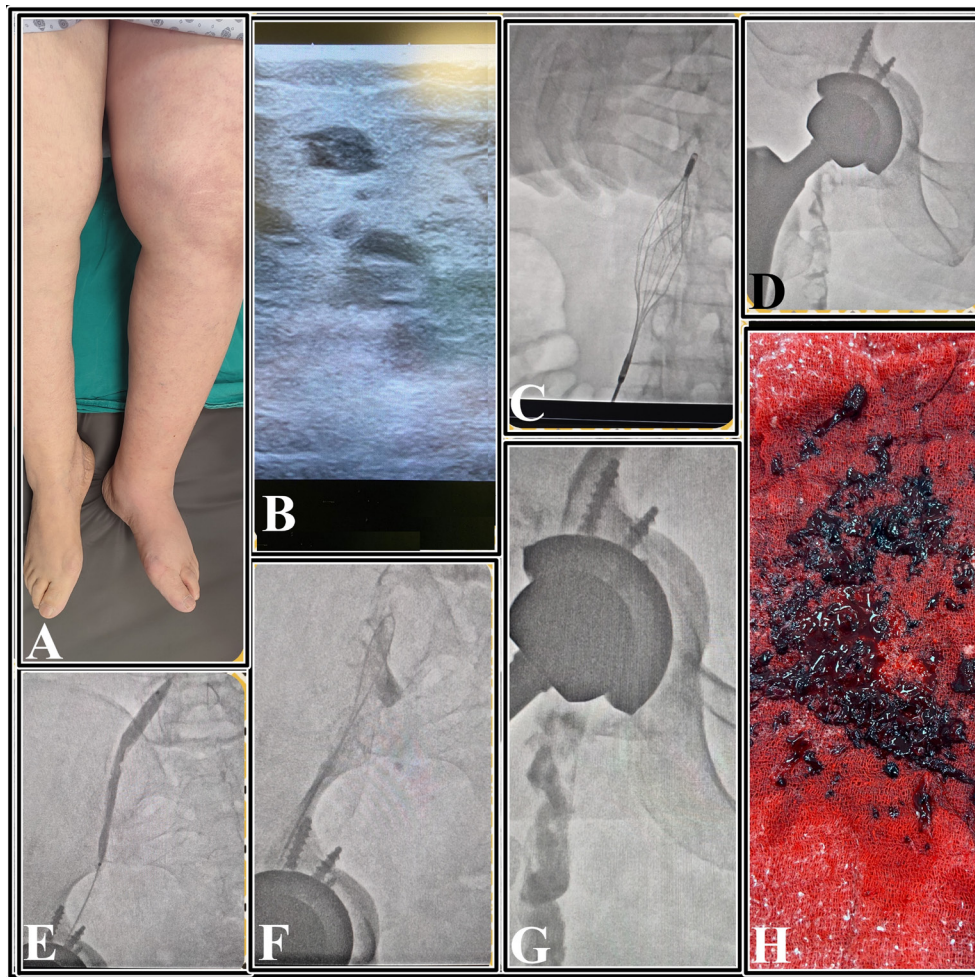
(A) An elderly female patient with a history of hip replacement surgery a month ago, who presented with warmth, discoloration, pain and swelling in her left leg. (B) Thrombus material in the femoral vein on ultrasonography. (C) Insertion of IVC filter. (D) Initial ascending venograms demonstrate significant occlusions of iliofemoral veins segments. (E) Plain old balloon angioplasty was performed due to residual venous stenosis following PMT. (F) Mantis catheter in the iliofemoral segment. (G) Completion venogram shows good flow into the vein segments. (H) Aspirated thrombus materials
